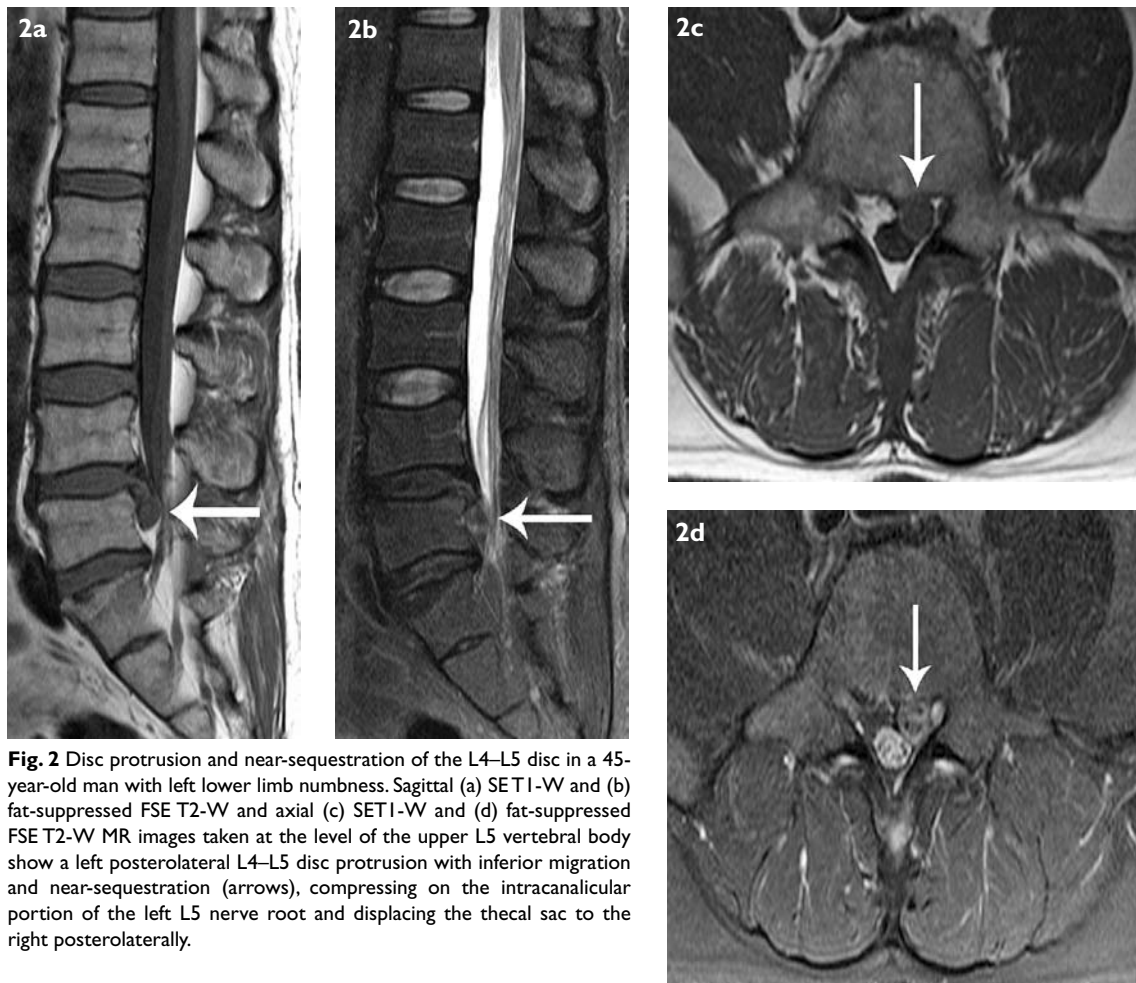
Disc protrusion and near-sequestration of the L4–L5 disc in a 45-year-old man with left lower limb numbness. Sagittal (a) SET1-W and (b) fat-suppressed FSE T2-W and axial (c) SET1-W and (d) fat-suppressed FSE T2-W MR images taken at the level of the upper L5 vertebral body show a left posterolateral L4–L5 disc protrusion with inferior migration and near-sequestration (arrows), compressing on the intracanalicular portion of the left L5 nerve root and displacing the thecal sac to the right posterolaterally.
